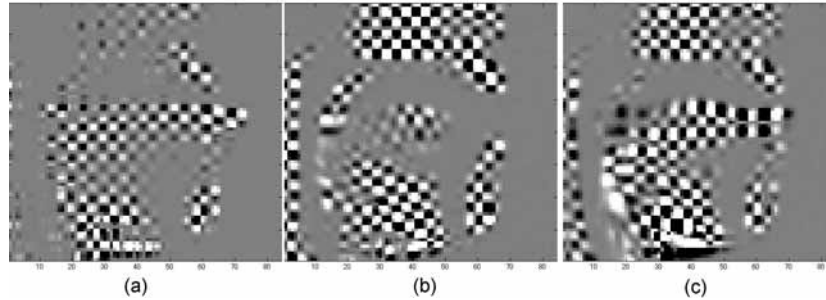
Tagged MR image of a protrusion-retraction-protrusion movement, (a) Frame 1 of the midsagittal plane where tongue is in an extreme protrusion, (b) Frame 12 of a parasagittal plane the tongue in a retraction position, and (c) Frame 25 of the same parasagittal plane where the tongue protruded again.
